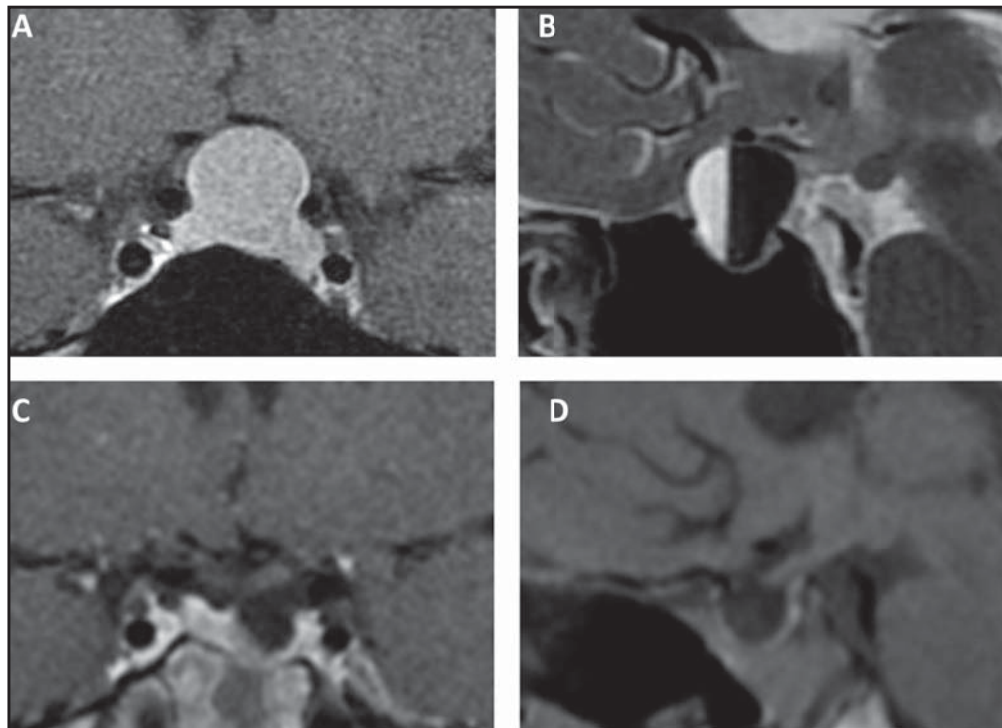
Pre- and postoperative MR images. (A) Preoperative coronal section of Gd-enhanced T1-weighted image (WI) showing an intrasellar mass extending into the suprasellar region. (B) Preoperative T2WI showing a mass containing a clear fluid–fluid level, indicating intratumoral hemorrhage. (C) Postoperative coronal section of Gd-enhanced T1WI showing decompressed chiasma and pituitary gland. (D) Postoperative sagittal section of T1WI revealing a hyperintensity area from the pituitary stalk to the posterior part of the pituitary gland, indicating preservation of posterior pituitary function.
